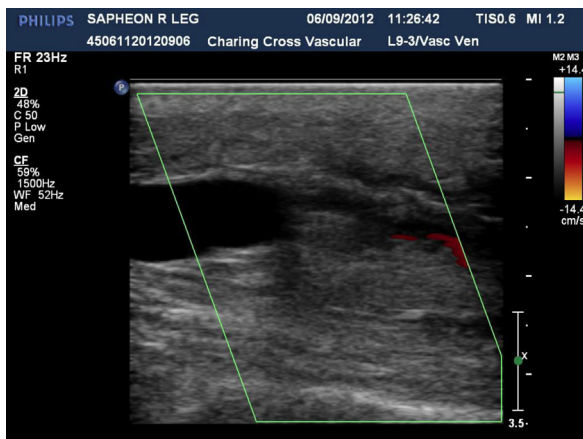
Duplex ultrasound imaging shows patent proximal great saphenous vein (GSV) with partial occlusion and reopening distally.
